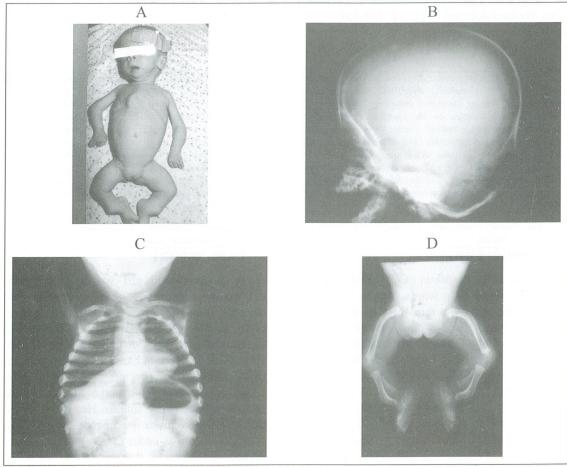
The appearance of the 14-month-old child with the clinical diagnosis of CD (A). Lateral cranial X-ray; Facial hypoplasia and micrognathia are evident (B). PA thorax roentgenogram: Narrow, bell-shaped thorax and hypoplastic scapulae are striking. There is no sternal mineralisation (C). Frontal projection of the pelvis and lower extremities: Note narrow iliac wings, increase in the acetebular angles, dislocation of the hip joints, insufficent mineralisation of the public bone, femoral and tibial angulation, hypoplastic fibulas and lack of mineralisation of the epiphysis except for in the femur distals (D).
